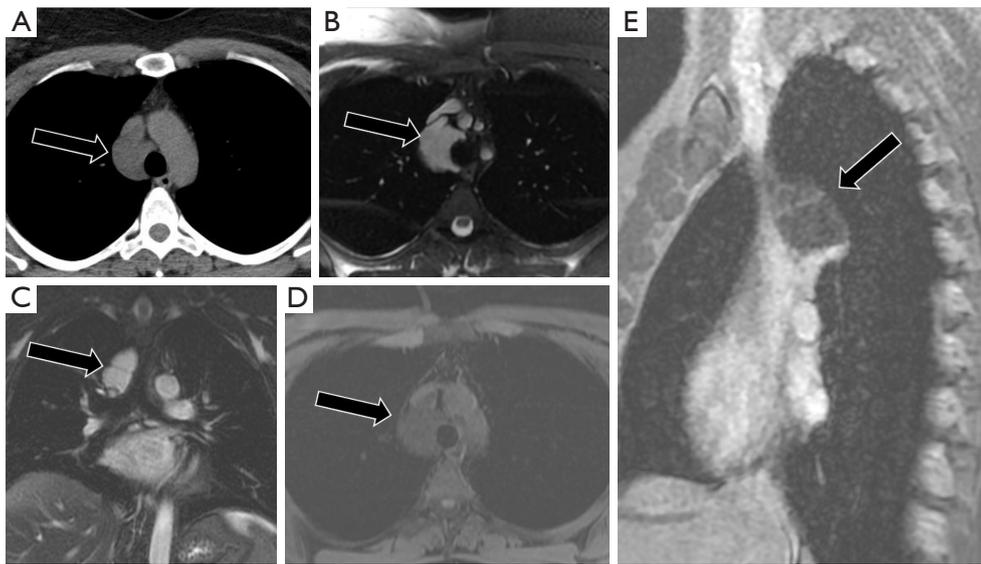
43-year-old female with lymphangioma. CT demonstrates a lobulated hypodense lesion in the visceral compartment (A, black arrow). MRI demonstrates a multiloculated T2W hyperintense (axial, B, black arrow; coronal, C, black arrow), T1 intermediate lesion (D, black arrow) with a thin enhancing septation (E, sagittal, black arrow), consistent with lymphangioma. CT, computed tomography; MRI, magnetic resonance imaging.
